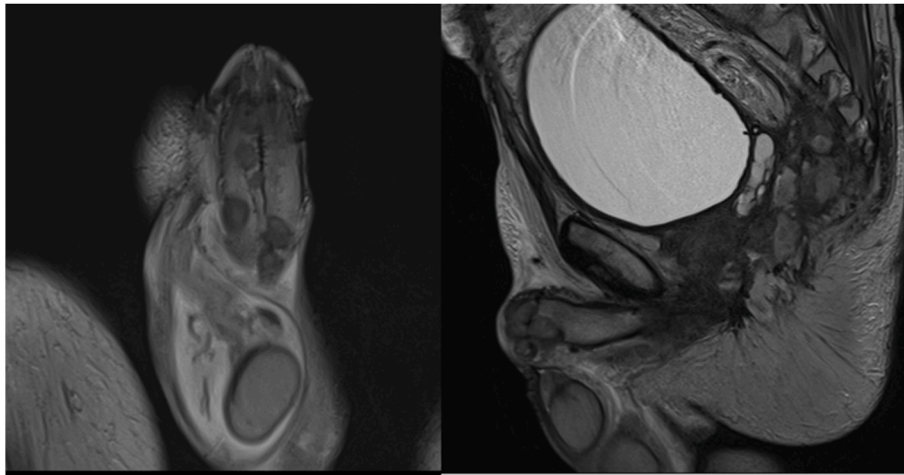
Axial and sagittal T2-weighted MR images show several bilateral small-sized low signal intensity nodules at both corpora cavernosa, corpus spongiosum and the glans penis.
